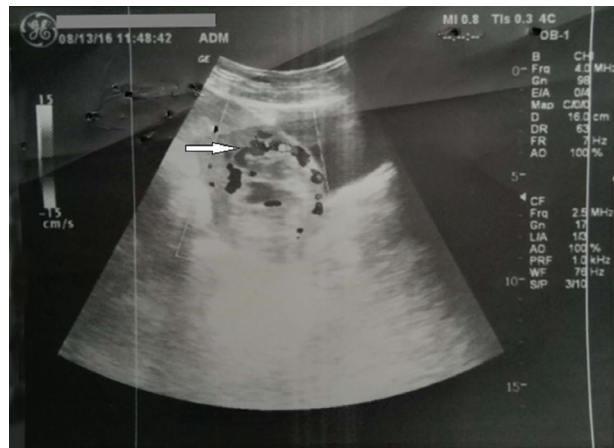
On color Doppler ultrasound, blood flow is seen in anterior cervical wall and vessels are traversing to the gestational sac indicating implantation.
